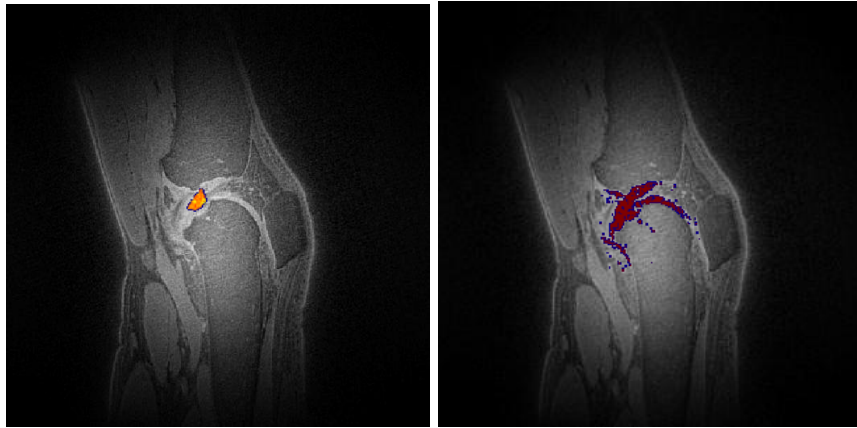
Segmentation procedure (a) ROI drawn on the center sagittal slice shown in orange overlay on the MRI (b) the resulting segmentation on the corresponding slice.
